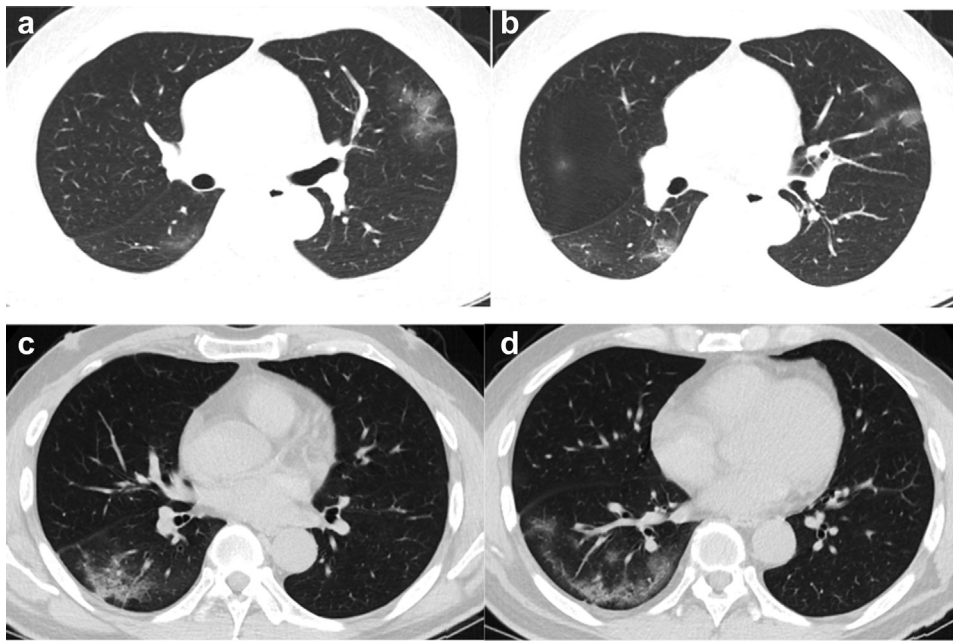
Baseline CT images (a-d) of a 50 year-old man admitted for symptoms of fever for 1 day: there were multiple patchy ground-glass opacities in the left upper lobe and right lower lobe (a, b). Air bronchogram and crazy paving pattern can be seen (c). Lesions are located in the peripheral area of the lung (d).
